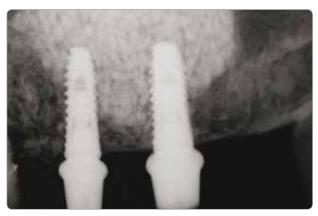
Connected abutment P.A. radiography
